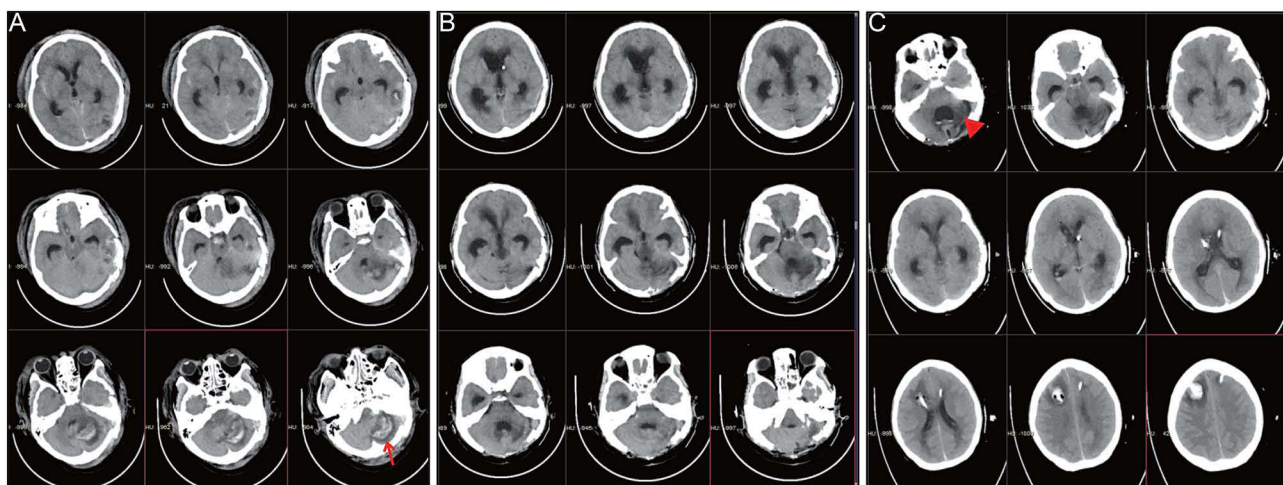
Patient's brain computed tomography. (A) The first brain CT in our hospital. Red arrow represents left cerebellar hematoma. (B) On the 15th day of hospitalization, the patient had sudden bilateral pupillary dilatation and the brain CT revealed hydrocephalus. (C) CSF culture was negative, and the brain CT revealed hydrocephalus relief; however, there was a separation of the fourth ventricles. Red arrow represents the fourth ventricle dilated.
